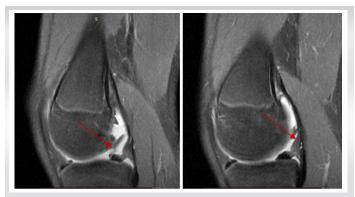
Sagittal magnetic resonance image shows the "flag sign," a meniscal fragment (arrow).
